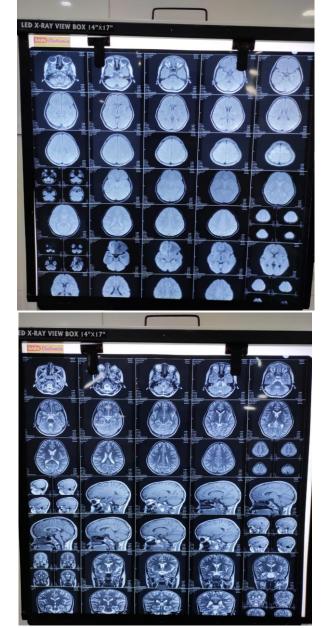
& 2 both depict MRI of brain representing horizontal, sagittal and coronal sections showing no abnormality
